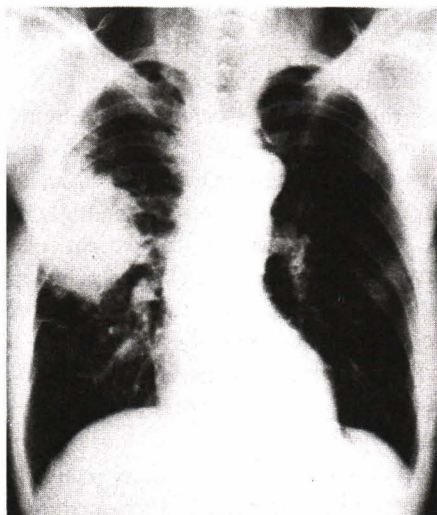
Chest roentgenograph show mass like shadowing in right upper lung zone.
